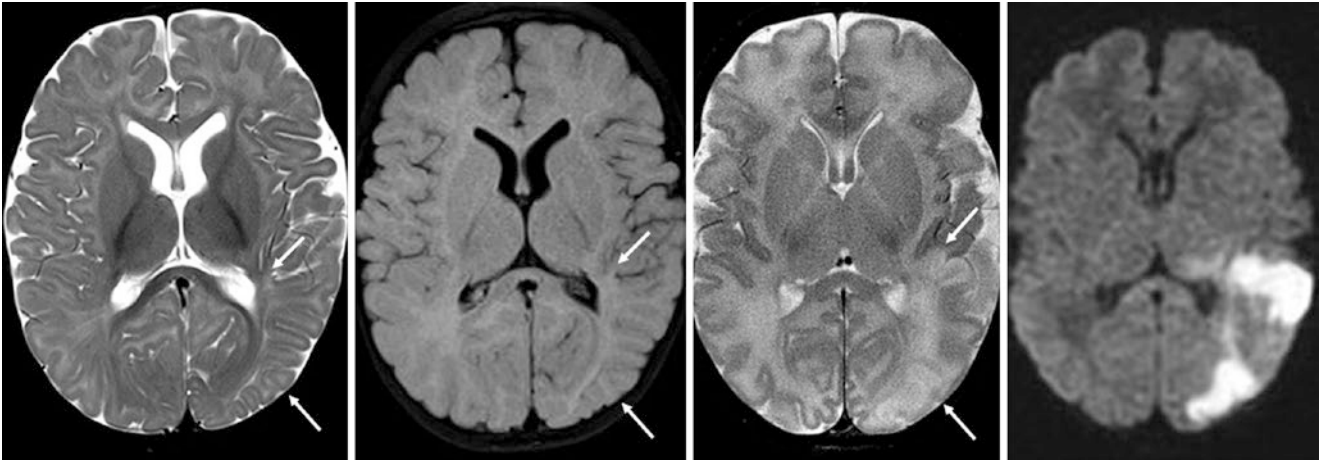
Comparison case of sequela of infarction. A 7-month-old with right-sided weakness had a 3T MRI that showed thinning of the left optic radiations white matter, with overlying small, shrunken gyri (*thin arrows*) on T2WI (*left*) and FLAIR (*left middle*), as well as
